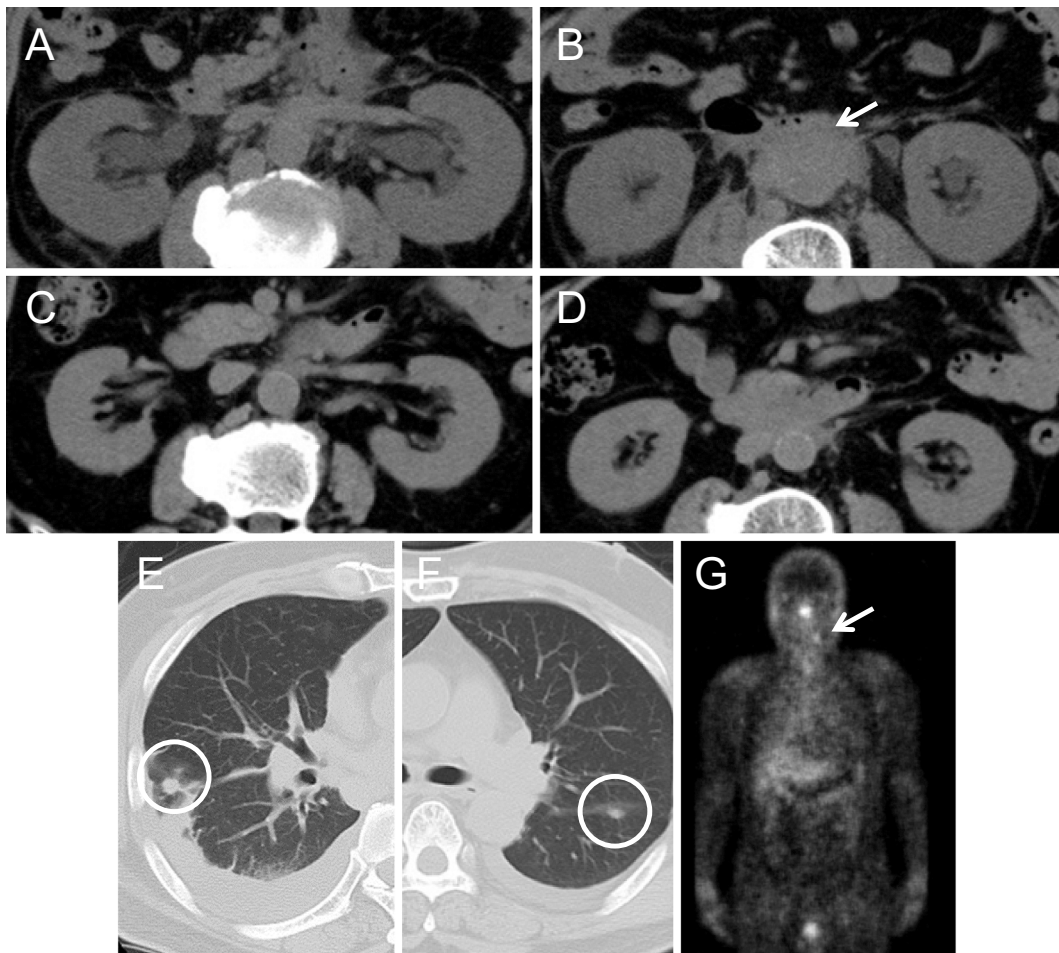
A: A CT image showing bilateral hydronephrosis before steroid treatment. B: A retroperitoneal mass before steroid therapy. C: A CT image of the kidneys after three months of steroid therapy. D: The retroperitoneal mass after three months of steroid therapy. E: A pulmonary pseudotumor on the right lobe before steroid treatment. F: Pulmonary pseudotumor on the left lobe before steroid treatment. G: Gallium-67 scintigraphy taken on the fifth day of steroid therapy, showing the positive uptake in the left mandibular gland (arrow).
